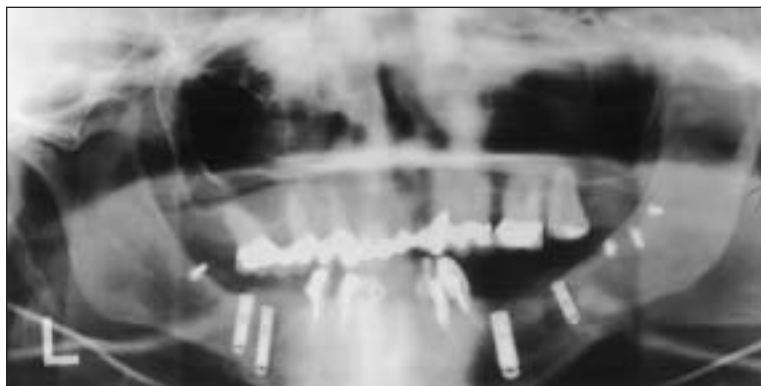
Panoramic radiograph showing a fracture of the mandible associated with the anterior implant on the left side.
